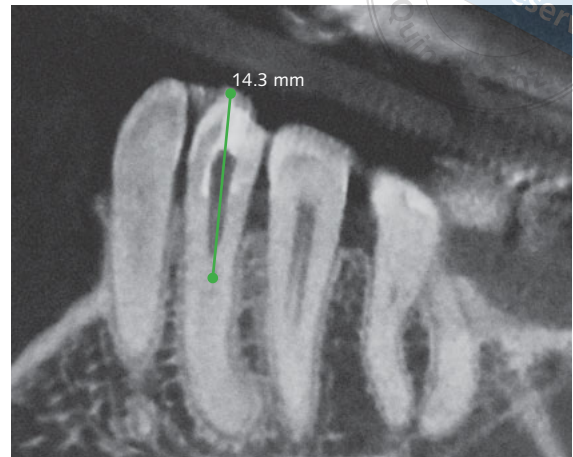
CBCT image. In a coronal section, the length was measured from the buccal cusp to the furcation level and was 14.3 mm.
